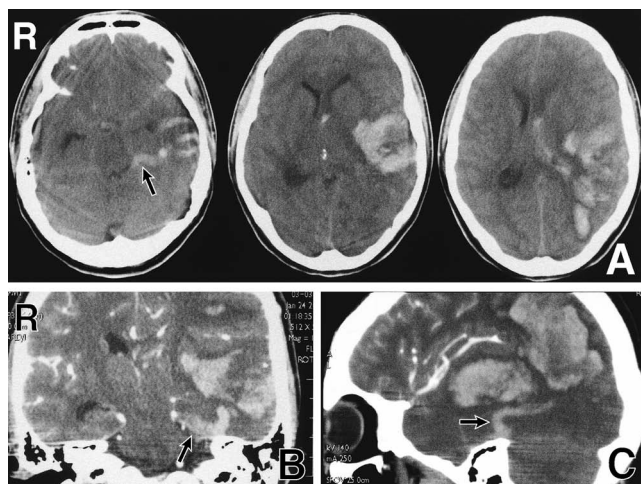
Computed tomography (CT) scans on admission (A) showing an irregular high density area compatible with hemorrhagic infarction in the left temporoparietal region associated with midline shift to the right, and a tubular high density area in the temporal lobe indicating vessel thrombosis (arrow). Coronal (B) and sagittal (C) reconstruction CT scans with contrast medium showing the three-dimensional configuration (arrow) of the tubular high density area indicative of a transcerebral draining vein of a venous malformation.
